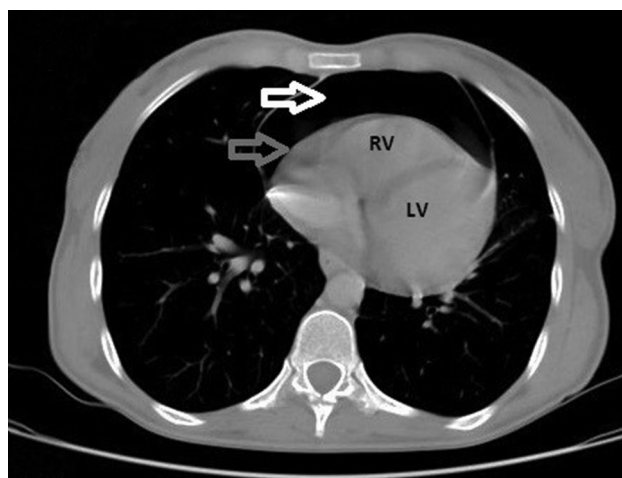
Chest computed tomography section displaying a marked pneumopericardium with an anterior extent (white arrow) associated with a small amount of pericardial fluid (grey arrow).
